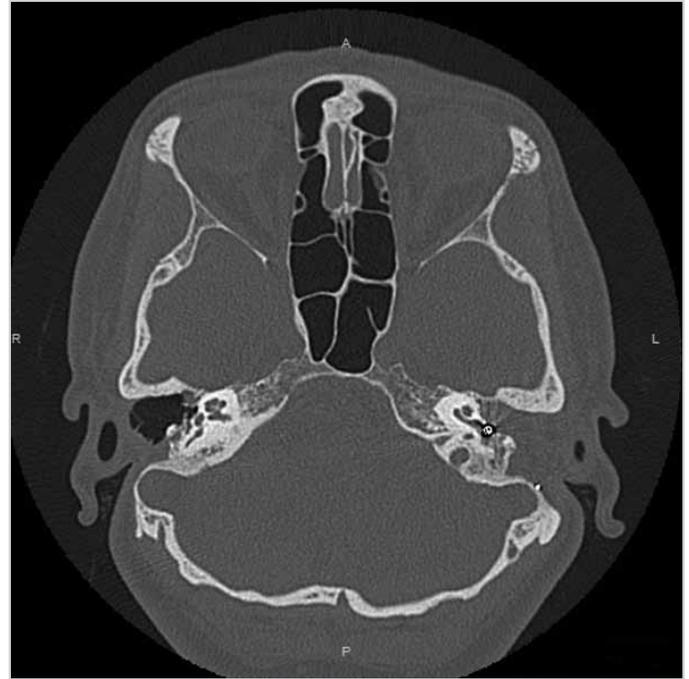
Postoperative CT image of a patient who had a VSB applied on the round window and cavity obliteration
